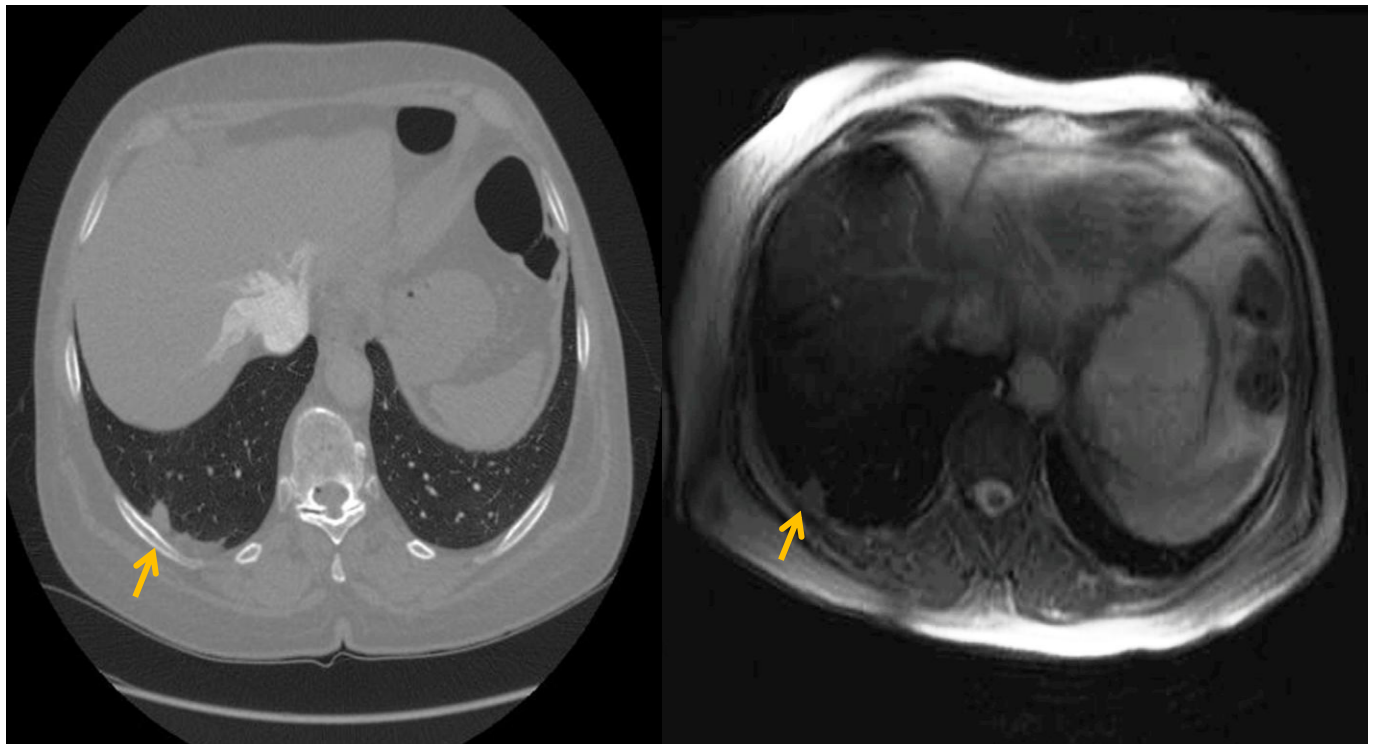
Small pleural based nodule seen on CT and MRI
